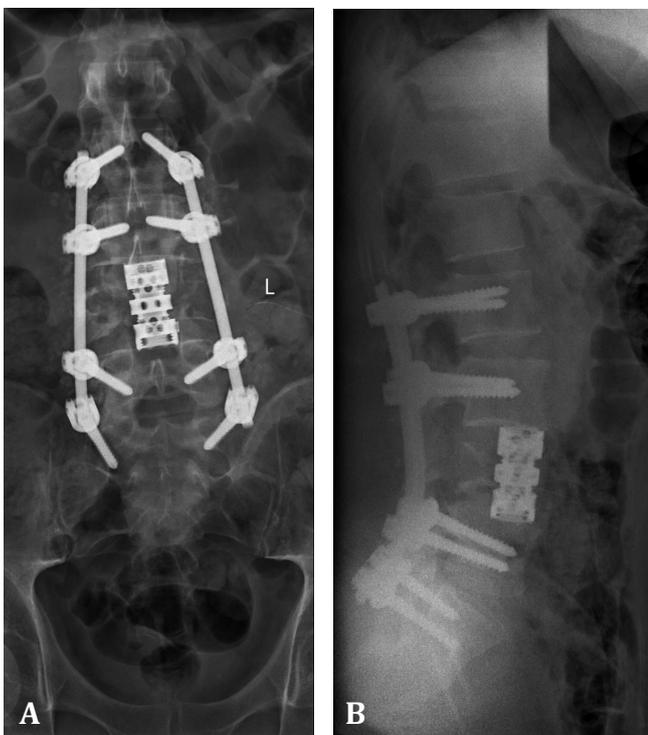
Lumbosacral radiograph after the second stage of surgery. A) Anteroposterior radiograph. B) Lateral radiograph.
